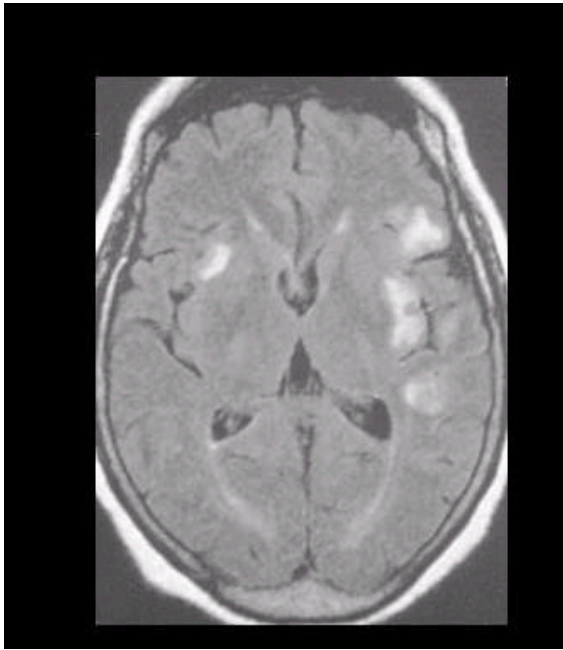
The patient's MR images at 7th month
